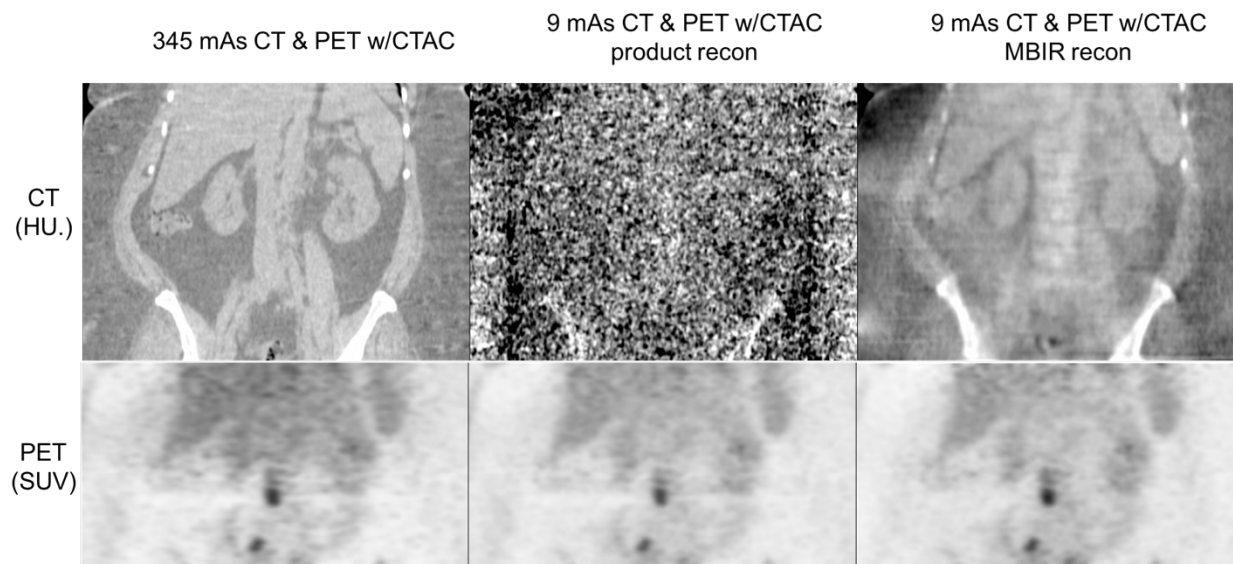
High and low-dose CT images and their correspondent PET images from the Patient 2 study
